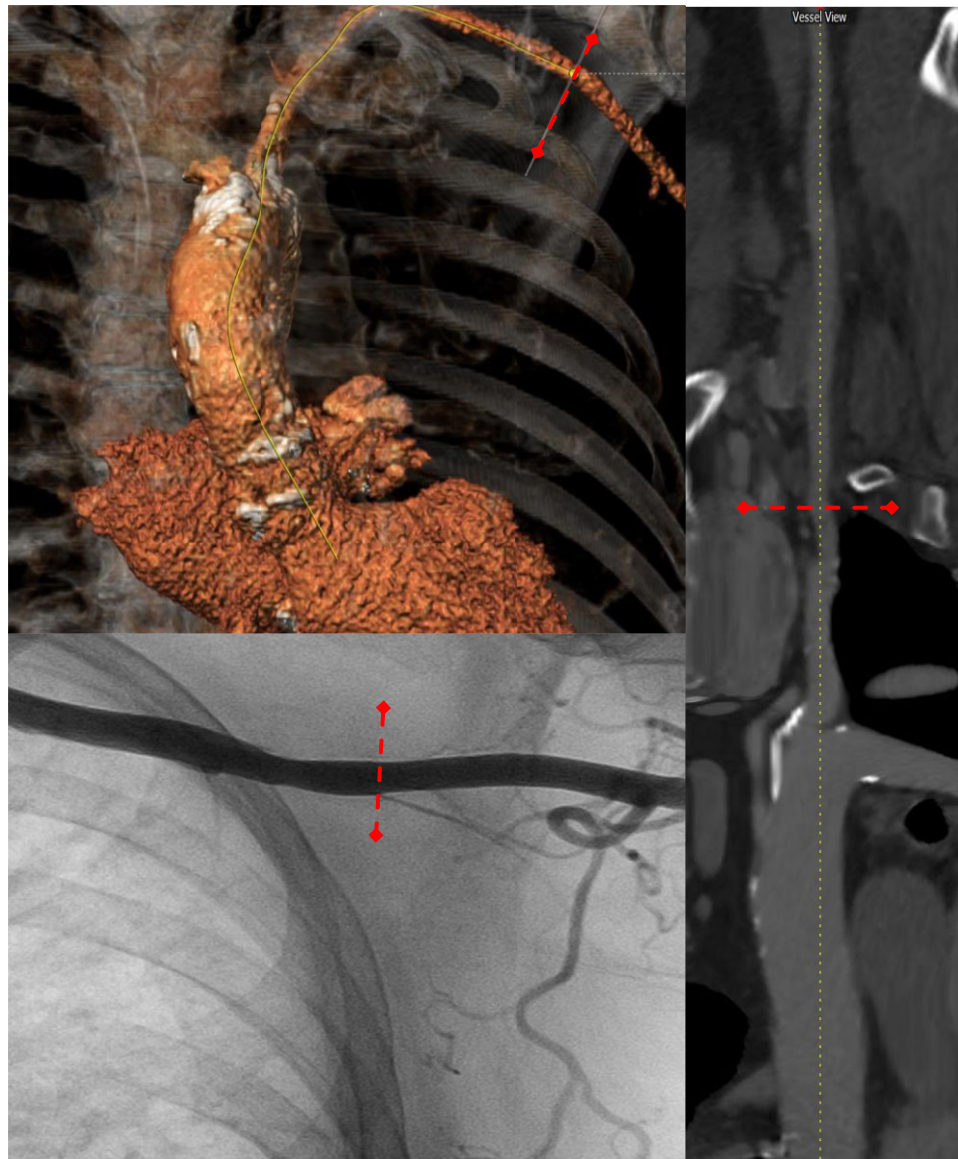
Planning computed tomography scan and angiography of the puncture site left axillary artery ideal puncture area (dotted line) at a distance to the lateral border of the rib cage to prevent artificial puncture of the pleural cavity.
